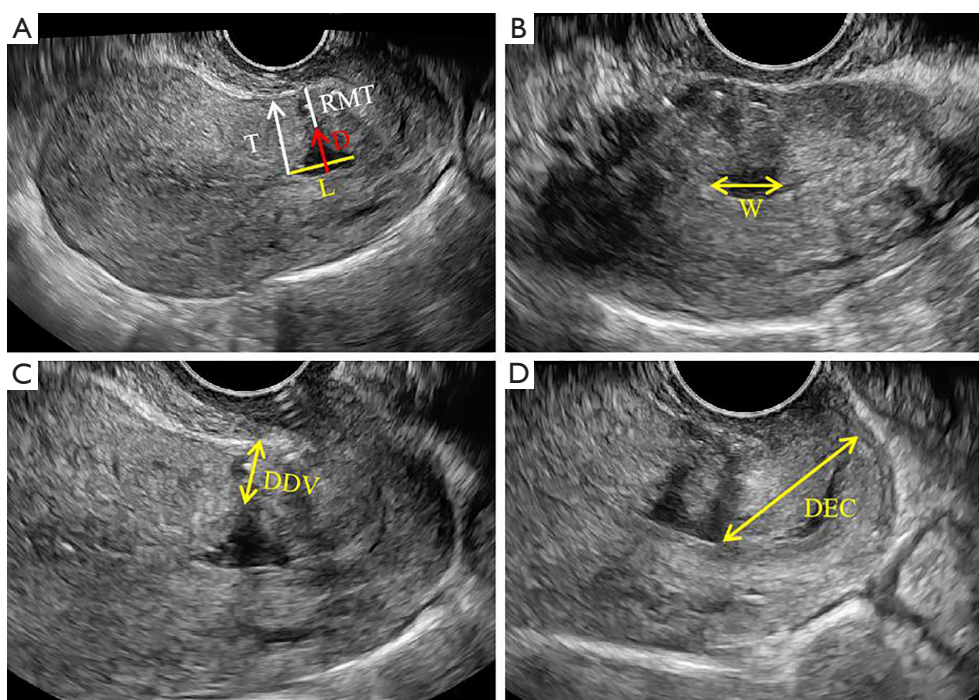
Ultrasonic indicators measurement of cesarean scar defect. (A) L represents the length of the defect (yellow line), D represents the depth of the defect (red arrow line), RMT represents the thickness of the residual muscle layer (white line), and T represents the thickness of the adjacent muscle layer (white arrow line). (B) W represents the width of the defect (yellow double arrow line). (C) DDV represents the distance from defect to vesico-vaginal fold (yellow double arrow line). (D) DEC represents the distance from the defect to the external cervix (yellow double arrow line). T, the thickness of the adjacent muscle layer; D, depth of the defect; L, length of the defect; RMT, residual muscle thickness; W, width of the defect; DVV, distance from defect to vesico-vaginal fold; DEC, distance from defect to the external cervix.
